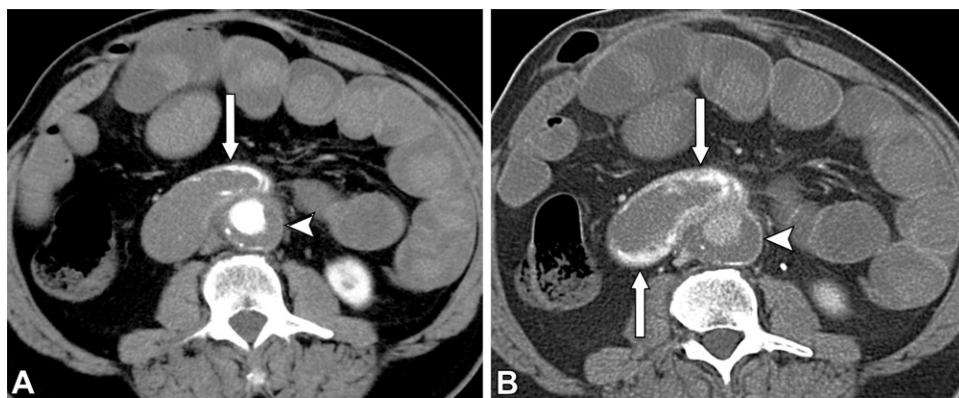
Aortic aneurysm with an aortoduodenal fistula and active bleeding in a 77-year-old man with a history of melena and anemia. Axial arterial phase (A) and late venous phase (B) CTA images show contrast extravasation in the distal duodenum in the arterial phase (arrow in A), which changes in size, attenuation, and shape in the late venous phase (arrows in B). Also noted is an abdominal aortic aneurysm containing eccentric thrombus (arrowhead in A and B).
